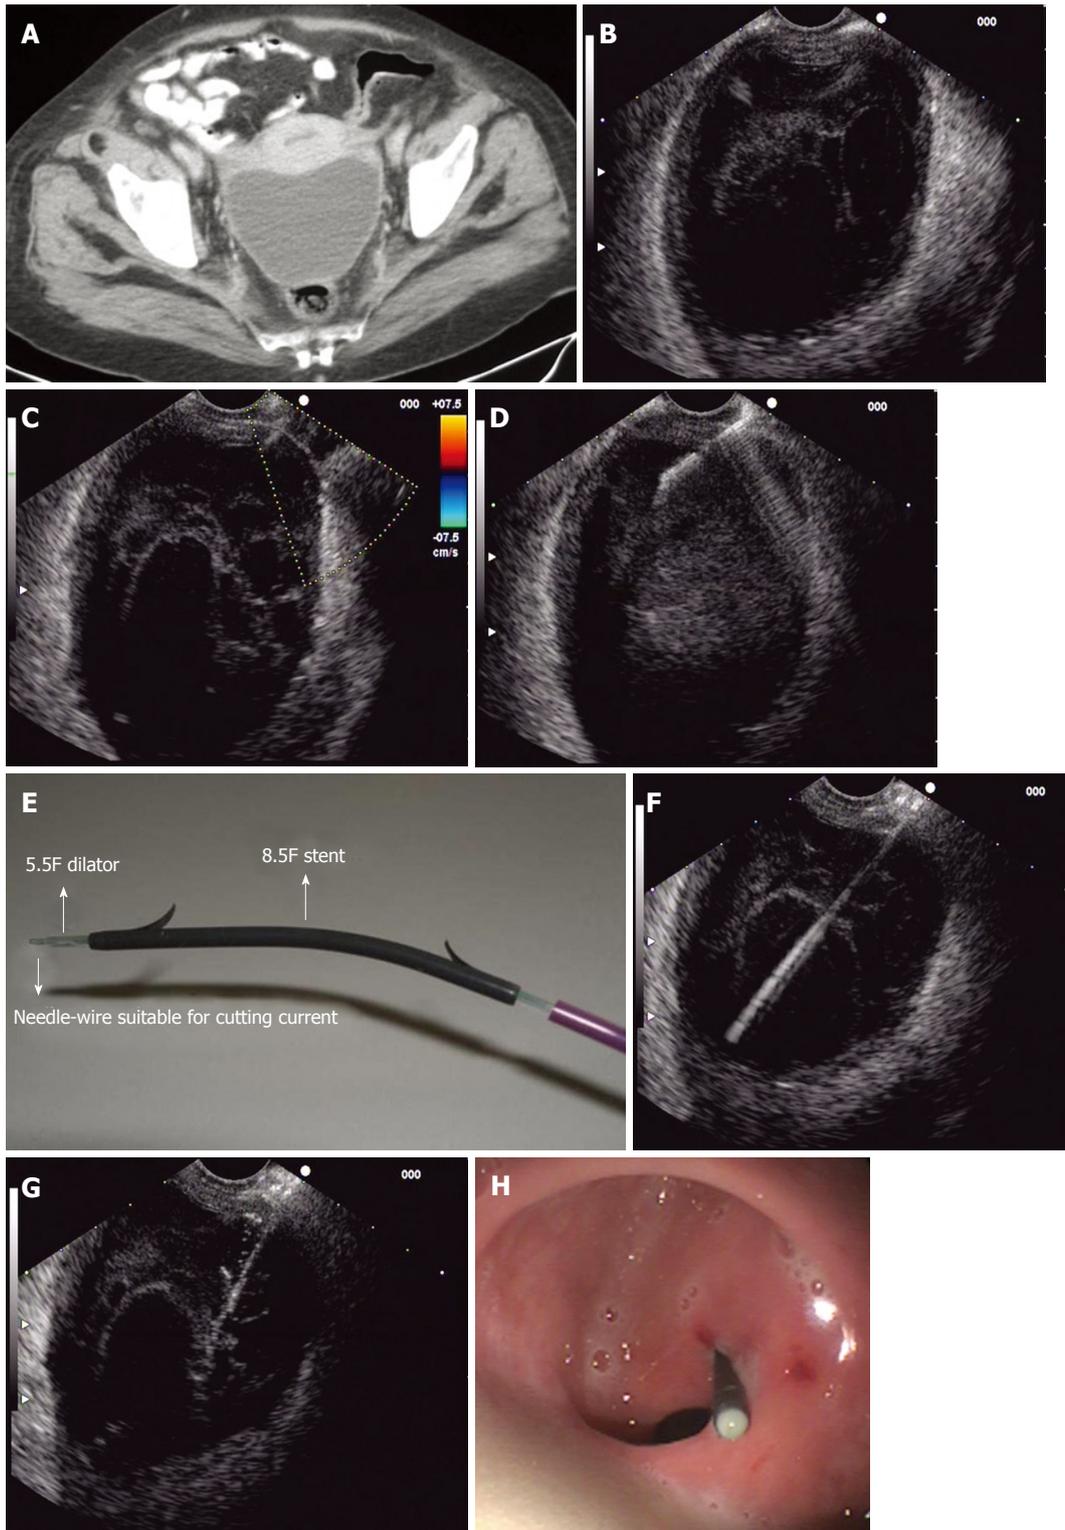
Endoscopic ultrasound (EUS)-guided pelvic abscess drainage procedure. A: CT scan showing a pelvic collection at the Douglas pouch; B: Pelvic abscess detected by linear EUS; C: Color-Doppler showing no vessels between the abscess and the puncture site; D: Fine-needle aspiration with a 19-G needle; E: NWOA system for one-step drainage of fluid collections; F: 0.035-inch needle-wire into the abscess cavity (NWOA system); G: An 8.5-F stent inserted into the abscess (NWOA system); H: Successful drainage.
